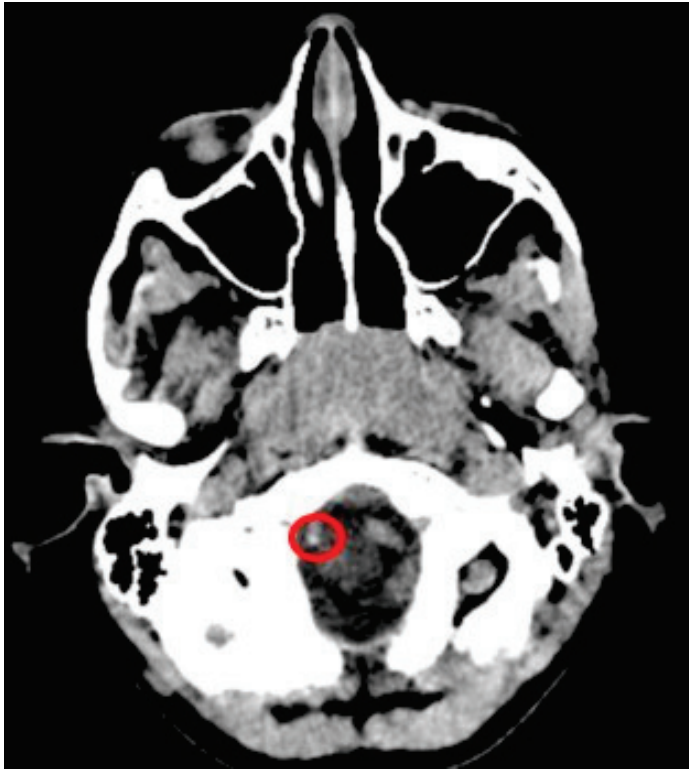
A 5-year-old girl with chronic otitis media; CT imaging of the temporal bone was performed. Hyperdense punctate calcification is shown in the V4 segment of the right vertebral artery (circle).
